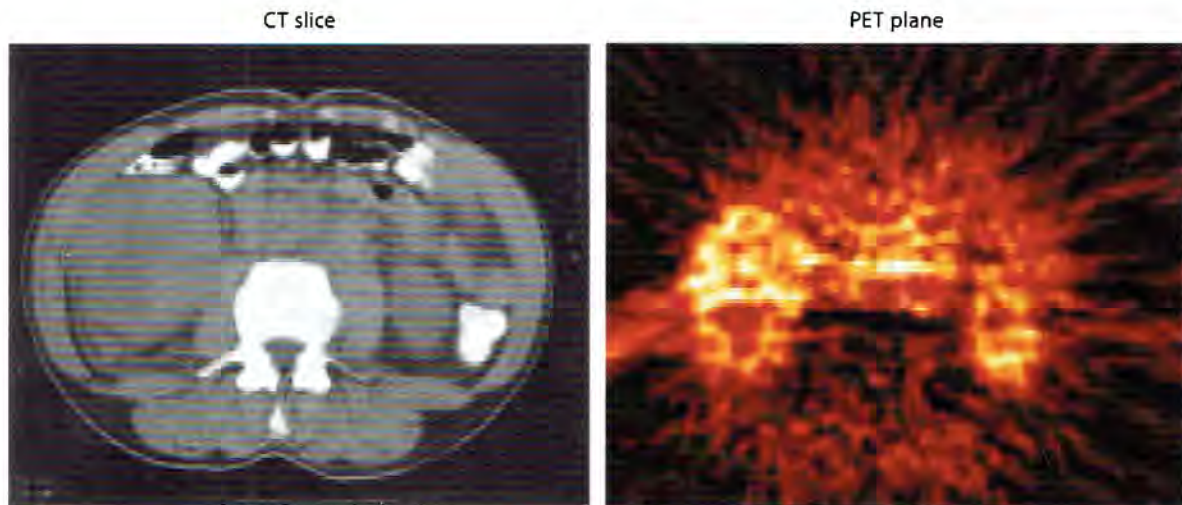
Axial CT scan through the mid-abdomen (*left*) and corresponding image from a summed PET ^{15}O -labelled H_2O study (*right*). Areas of increased brightness on the PET scan represent increased perfusion (the whiter the area, the higher the perfusion). The large right renal mass seen on the CT image represents a primary renal cell carcinoma. This is seen on the PET image as a bright area with a black centre representing a necrotic core. Vascular structures centrally, such as the aorta, are also bright. (Reproduced from Anderson et al. 2003a)
